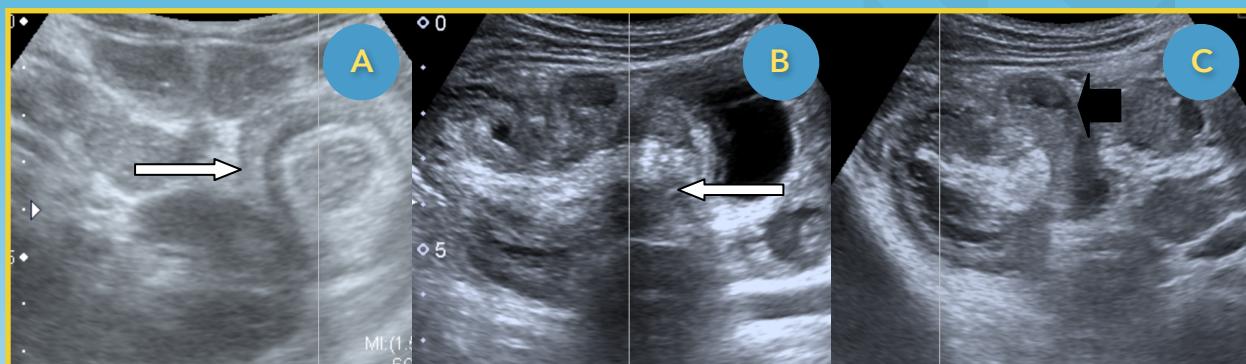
Ultrasonography Findings.
